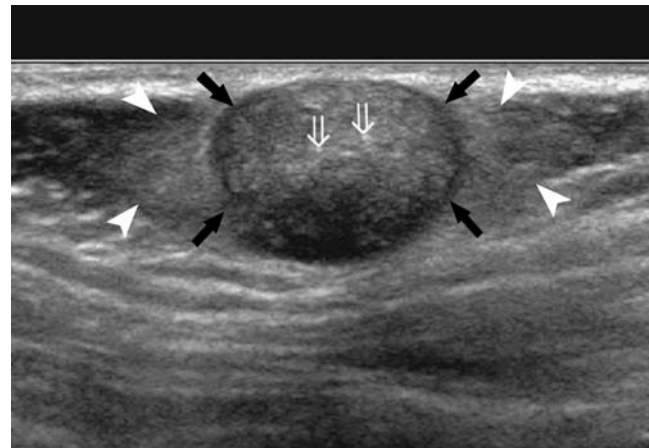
An 8-year-old boy with pilomatricoma. The sonogram shows a well-defined, hyperechoic mass in the posterior neck. The lesion has a hypoechoic rim (arrows), tiny echogenic spots (open arrows), and peritumoral hyperechogenicity (arrowheads) in the surrounding subcutaneous fat tissue
